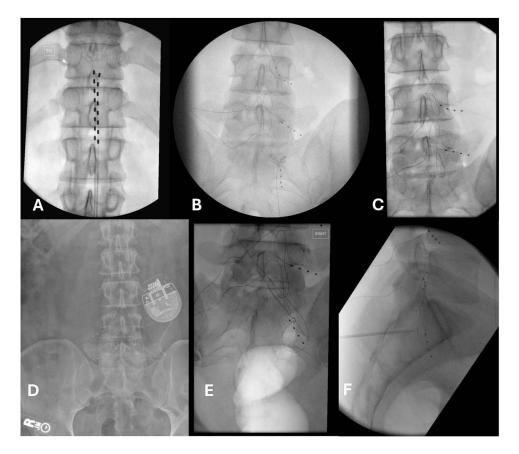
Figure I Fluoroscopy images of SCS and DRG stimulator lead placements. (A). SCS lead placements for the trial. (B). DRG lead placements for the trial. (C). DRG lead placements for the first implant. (D). Lumbar X-ray at 9 months after the first implantation. (E) and (F). Implantation of SI lead.
